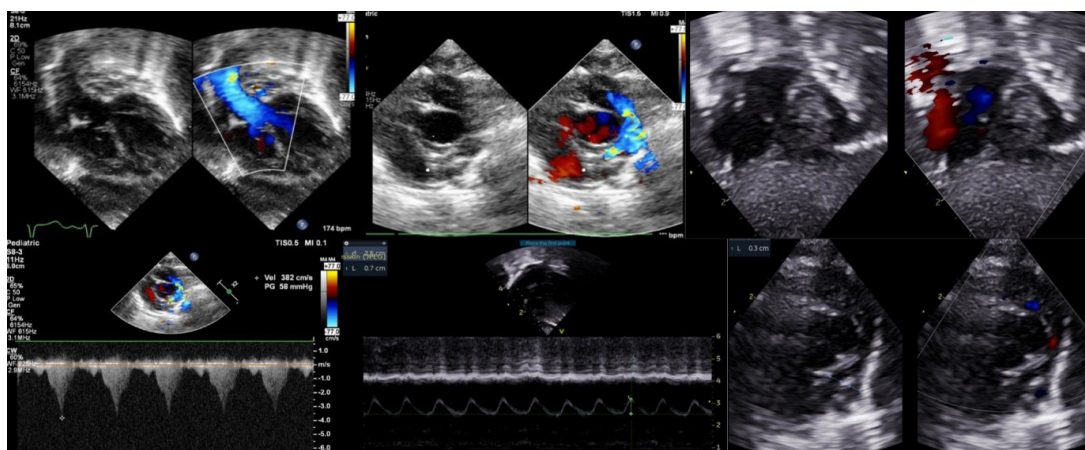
Pre-procedural echocardiography showing a ventricular septal defect with an overriding aorta (top left), infundibular pulmonary stenosis (top center), an atrial septal defect (top right), a pulmonary stenosis gradient of 58 mmHg (bottom left), reduced TAPSE (bottom center), and small pulmonary arteries (bottom right).
